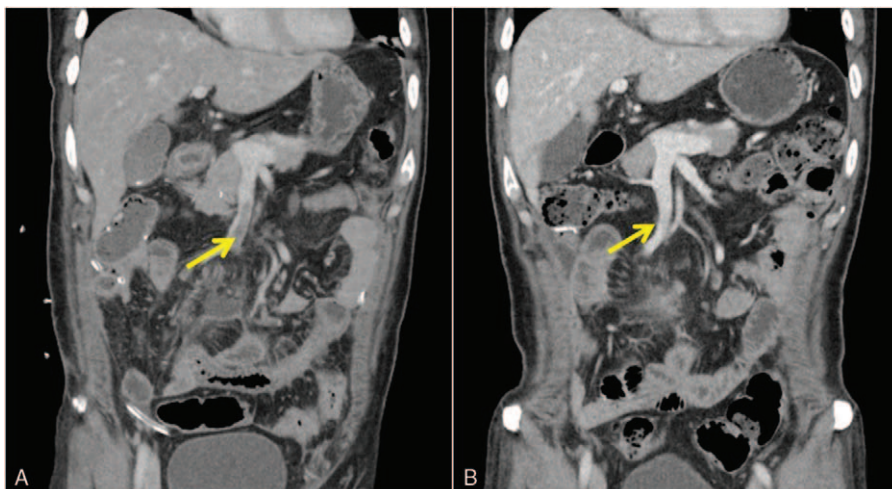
CT scans of patient 2 (A) 1 week after surgery and (B) after 3 months of anticoagulation.
